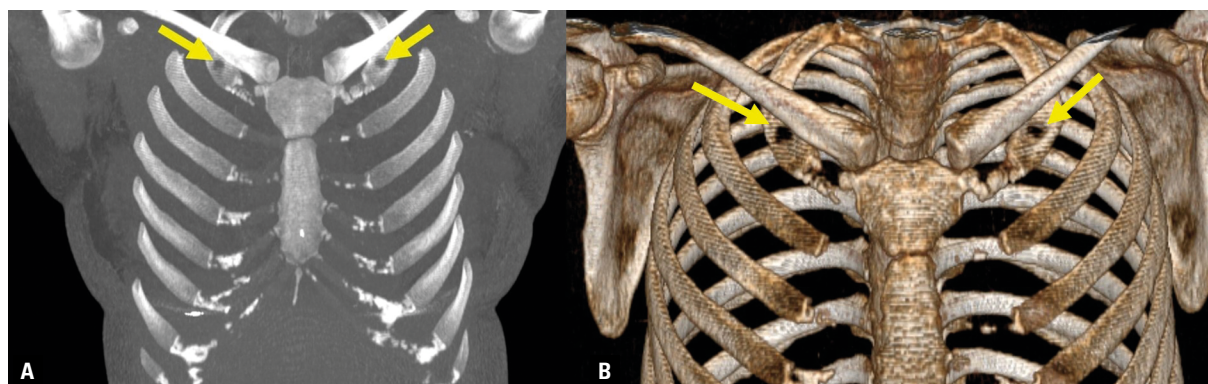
Presence of a single foramen on the first rib on both sides on the coronal computed tomography image (A) and three-dimensional image (B).
